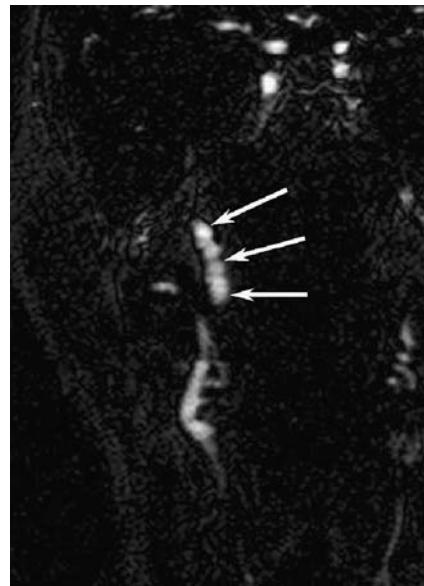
Fibromuscular dysplasia. Coronal contrast-enhanced T1-weighted image from an MR arteriogram demonstrates a beaded appearance (arrows) to the cervical ICA. This appearance can be seen in both vasospasm and fibromuscular dysplasia
